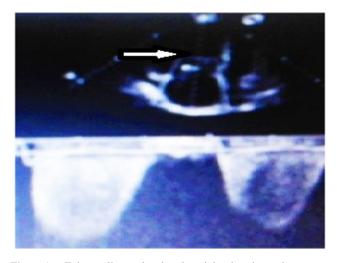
Echocardiography showing right chamber enlargement (arrow) and Doppler measurement of peak velocity of tricuspid regurgitation used for estimation of pulmonary artery systolic pressure.
